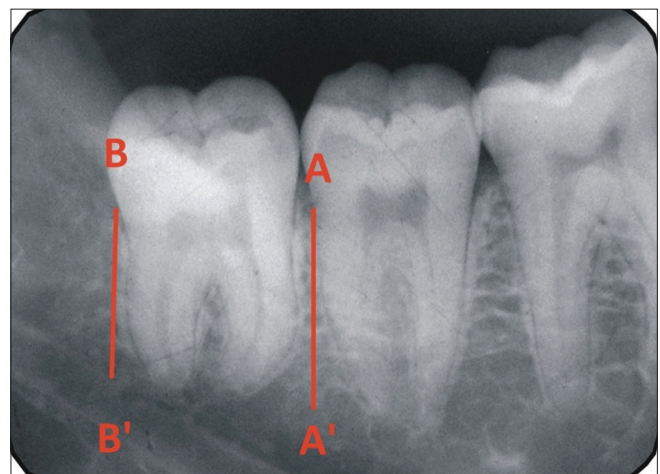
Intraoral periapical radiographs radiographic image showing method to evaluate bone density
